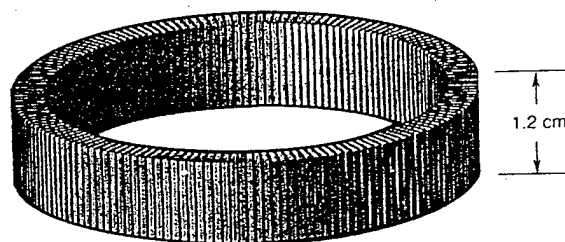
Scanning Geometry of Ultrasound Diffraction Tomography Breast Imaging System.
